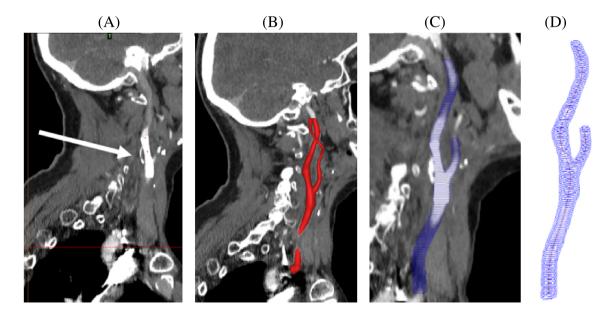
(A) CT image of post-stent carotid artery bifurcation showing metallic artifact due to the presence of stent metal. (B) Volume rendering and segmentation of the model from CT images before generation (C) polylines. (D) Both polylines and centerlines were exported to CAD files to reconstruct the lumen surface.
